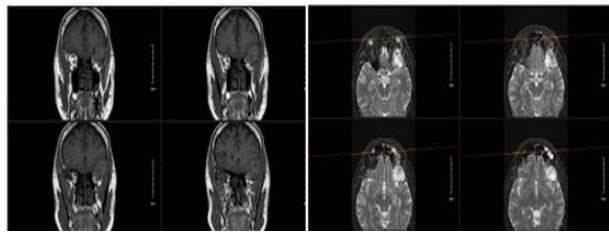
Orbital MRI before radiotherapy showing a 39 × 33 mm lobulated enhancing mass in the posterolateral left orbit along the sphenoid ridge, exerting significant pressure on the optic nerve and displacing the superior and lateral rectus muscles, corresponding to the patient's diplopia and orbital pain.
